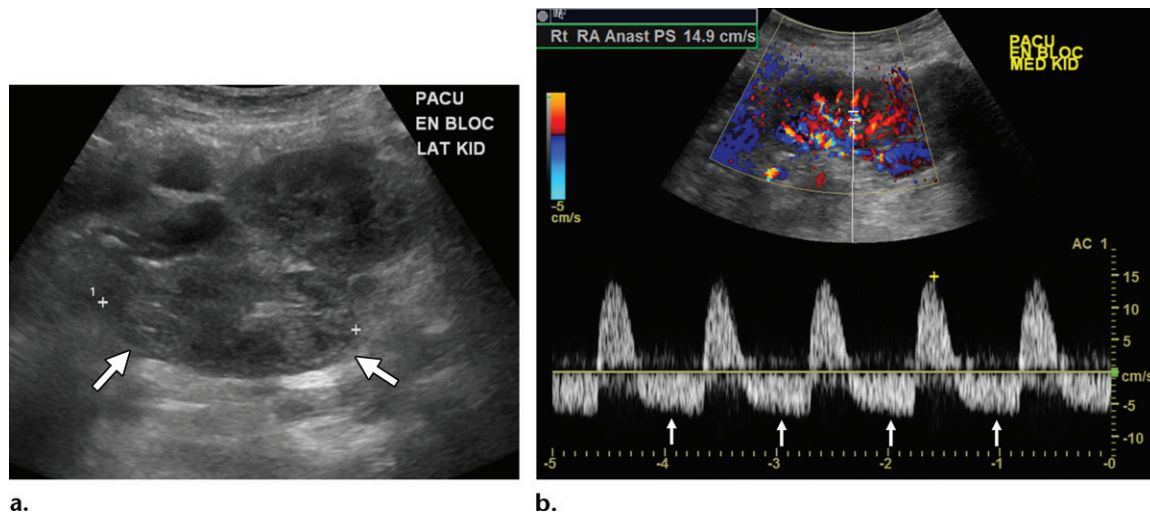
Perioperative renal vein thrombosis after transplantation of pediatric en bloc kidneys. (a) Gray-scale US image of en bloc pediatric kidneys shows heterogeneity of the lateral renal moiety (arrows). (b) Color Doppler image with spectral tracing of the intrarenal artery in the medial renal moiety shows classic reversed diastolic flow (arrows) with preserved systolic arterial upstroke, highly concerning for renal vein thrombosis, which was proved at allograft nephrectomy.
